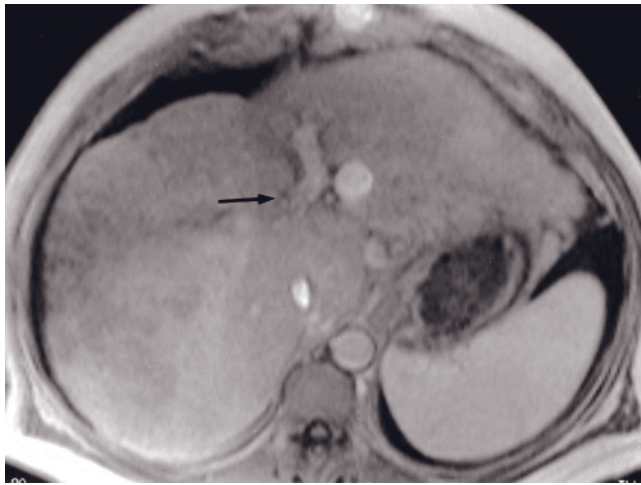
(Continued) Ring enhancing HCC. T1-weighted fat-suppressed 3D-gradient echo immediate post gadolinium images obtained at 3T in a 6-month interval between studies (g, h). Note the ring pattern of enhancement best observed on 6-month follow-up exam, which mimics the enhancement pattern of metastases. Ring enhancement may be a sign of a more aggressive HCC.
